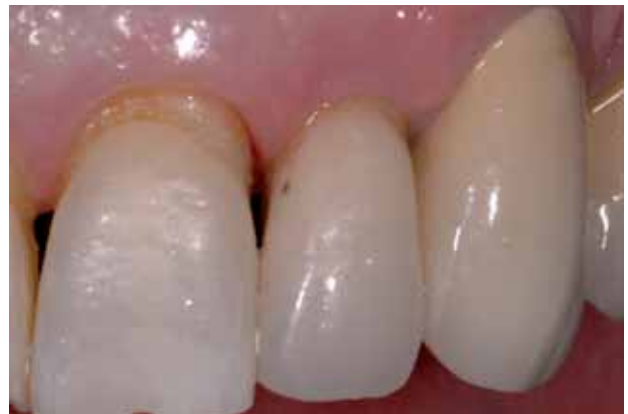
5b Final restoration with definitive crown and radiograph taken 18 months after surgery.
